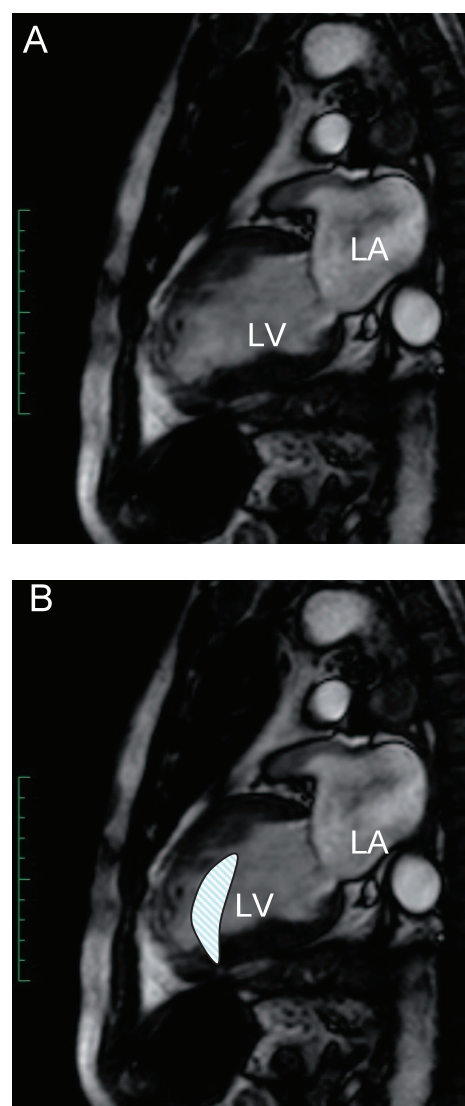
Sgittal plane view of a patients's heart with ventricular aneurysm taken by magnetic resonance imaging; Figure A (top) indicated the preoperative patient's heart, and the hatched area in Figure B (bottom) was the image of the region to be patched by surgical treatment using "Dor procerdure".
